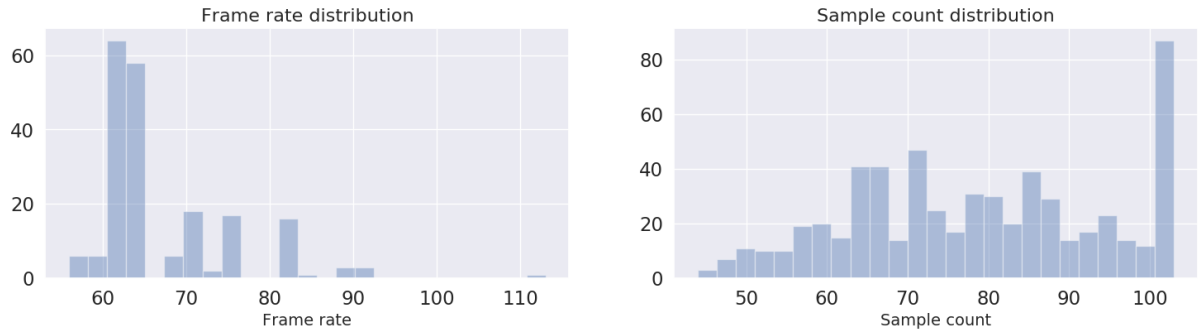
Distribution of the frame rate used in the ultrasound imaging used to obtain the strain curves (left), and sample count of the different strain curves (right).
